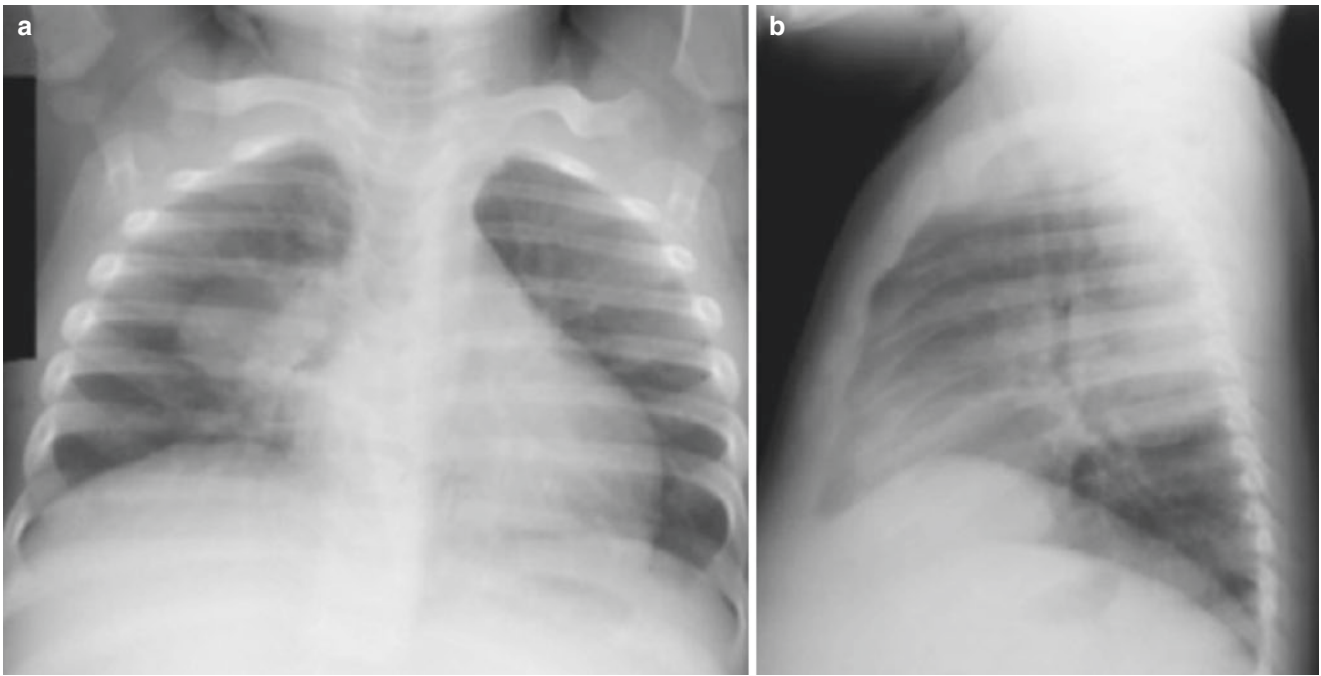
A 9-month-old girl with a 3-week history of cough and fever (102 °F). (a) Frontal and (b) lateral radiographs demonstrate a round mass-like opacity in the superior segment of the right lower lobe. After antibiotic therapy, the mass resolved and the chest radiograph returned to normal
